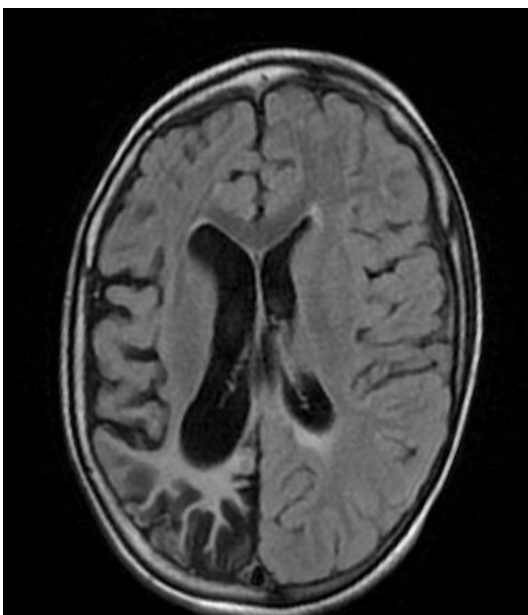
Axial FLAIR MRI brain reveals atrophy of right
